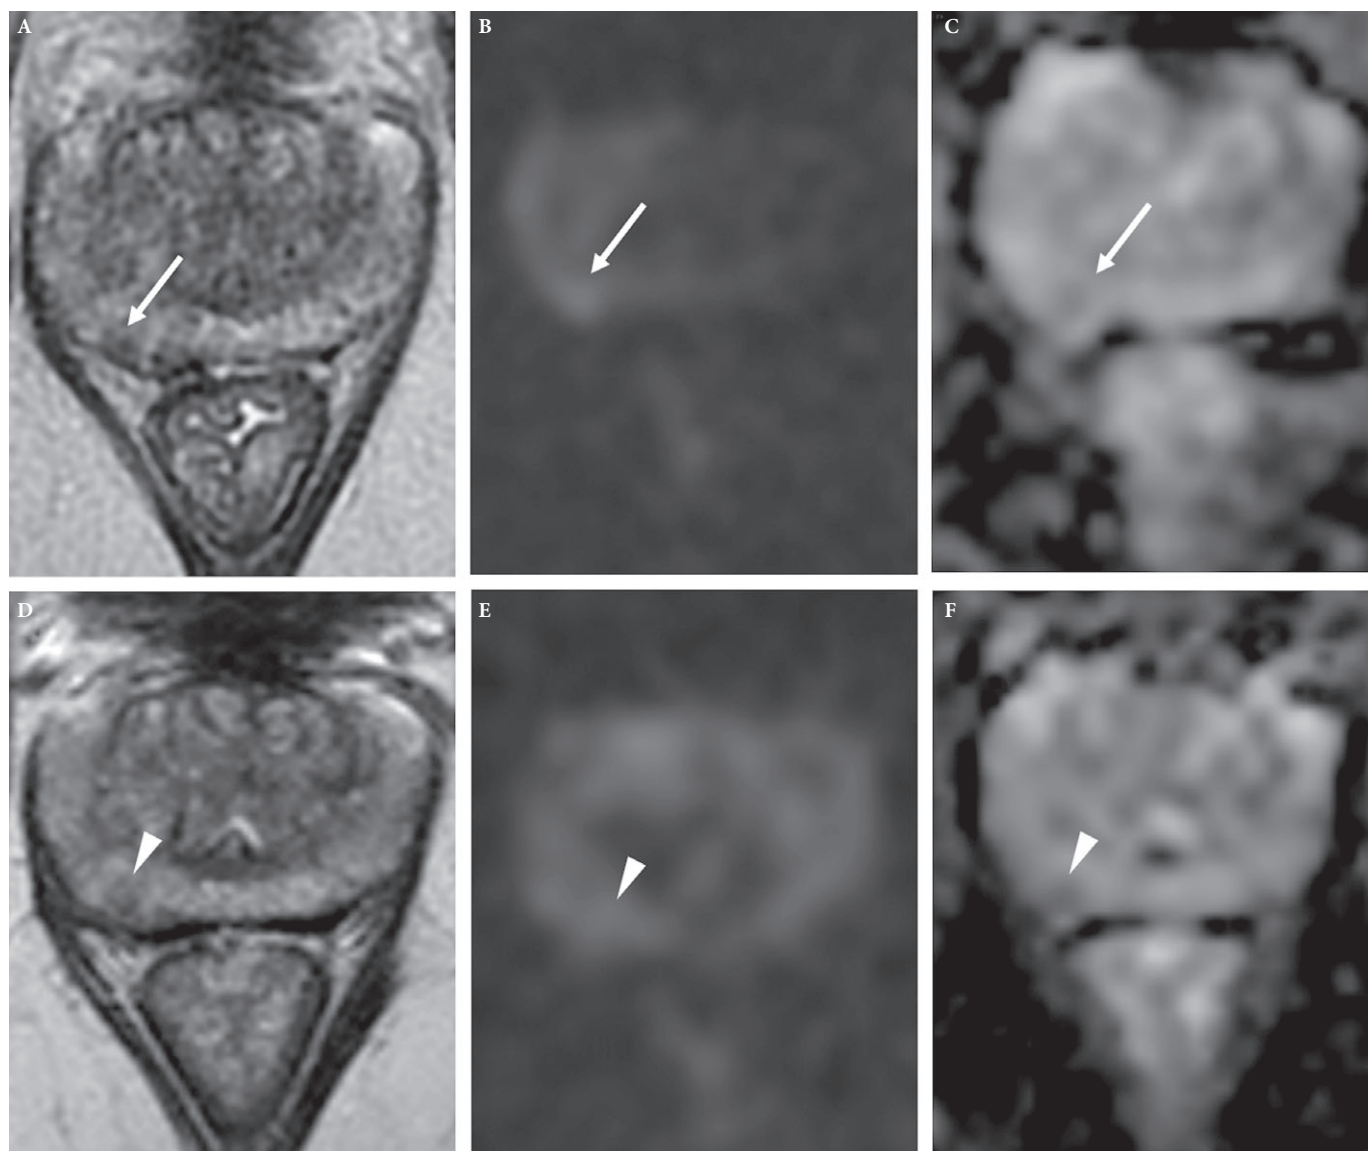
False-negative lesion in a 62-year-old patient with a PSA of 7.52 ng/mL. Ultrasonography/MRI fusion-guided biopsy revealed Gleason 3 + 3. (A–C) Fast MRI protocol without significant lesion, retrospectively visible (arrow) on T2-WI (A) with mild restriction of diffusion on high b value ($b = 2\,000\text{ s/mm}^2$) (B), and an apparent diffusion coefficient of $1.1 \times 10^{-3}\text{ mm}^2/\text{s}$ (C). Panels D–F mpMRI protocol PI-RADS 4 lesion of 4 mm (arrowhead) in the right postero-median peripheral zone with moderate restriction of diffusion (apparent diffusion coefficient: $1.04 \times 10^{-3}\text{ mm}^2/\text{s}$) and positive dynamic contrast-enhanced imaging (not shown).
